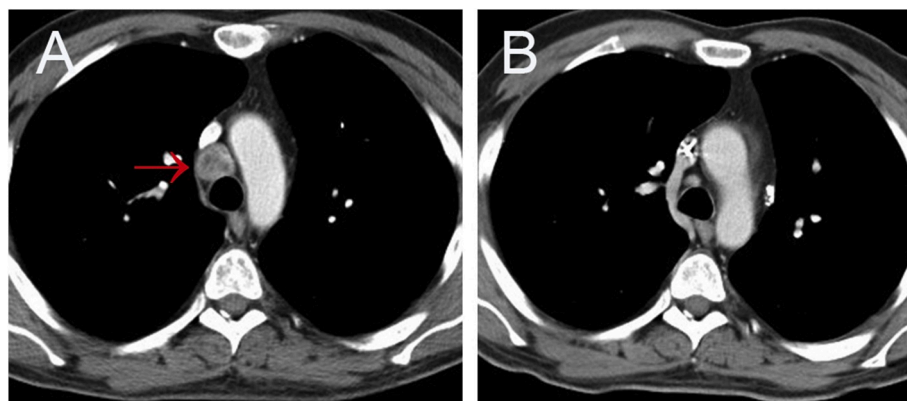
CT of chest showing (A) an enlarged pretracheal lymph node and (B) tumor response in lymph node after TIP chemotherapy.
